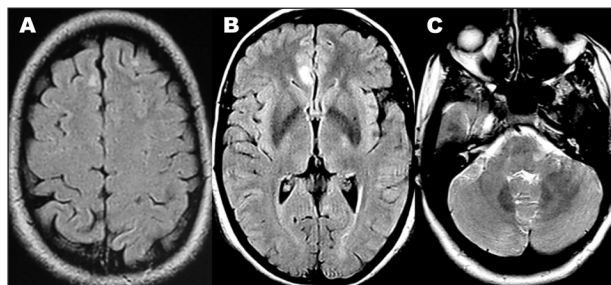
Brain MRI: (A) and (B), axial fluid-attenuated inversion recovery (FLAIR), show right subcortical frontal (A) and anterior ipsilateral periventricular (B) hyperintense lesions. (C) axial T2-turbo spin-echo (T2-TSE), reveal an hyperintense lesion localized in the left middle cerebellar peduncle.
